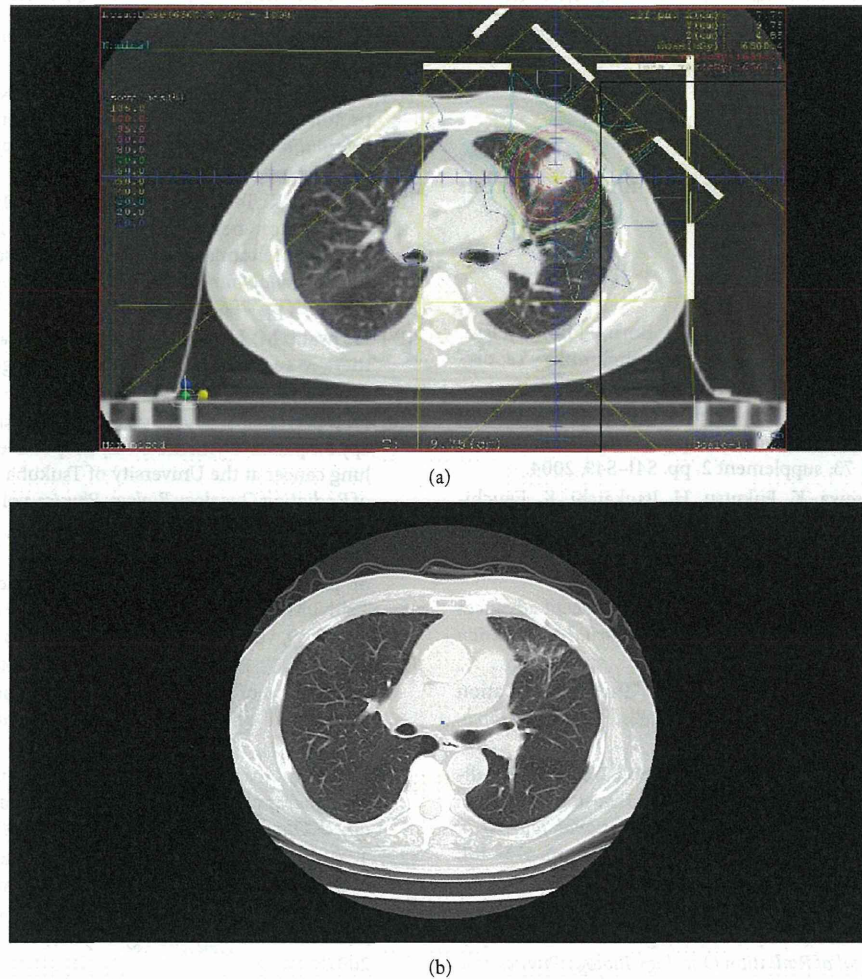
A patient with peripheral-type T2aN0M0 non-small-cell lung cancer that was treated with 66 Gy (RBE) of carbon ion therapy in 10 fractions. (a) Dose distribution. (b) A computed tomography image 5 months after carbon ion therapy.
